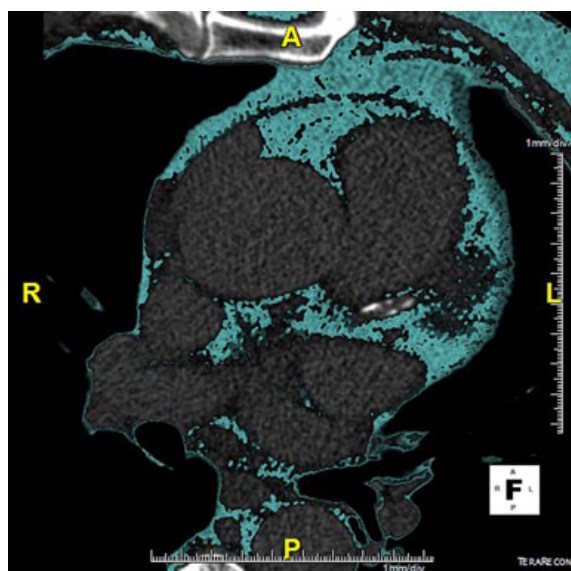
Multidetector computed tomography image of epicardial adipose tissue and left anterior descending coronary artery calcification.
